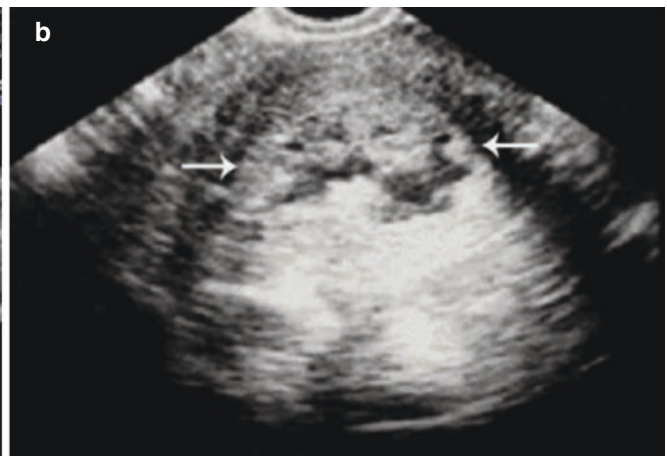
Endometrial polyp. A 29-year-old patient represented with menstrual disorder and infertility. Ultrasonography shows an enlarged uterus and heterogeneous echoes with a diameter of nearly 6.0 cm in the uterine cavity. Multiple polyps are diagnosed after curettage (arrow)
